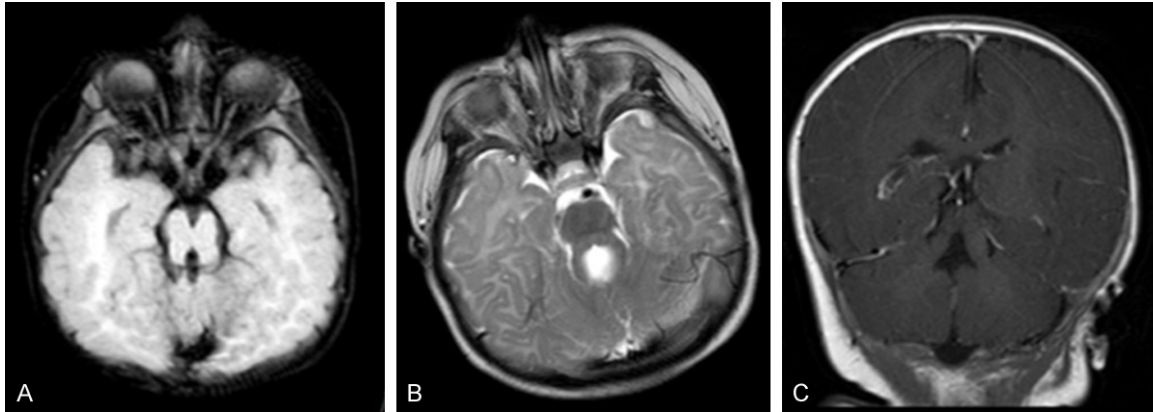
Molar tooth sign shown by MRI.
